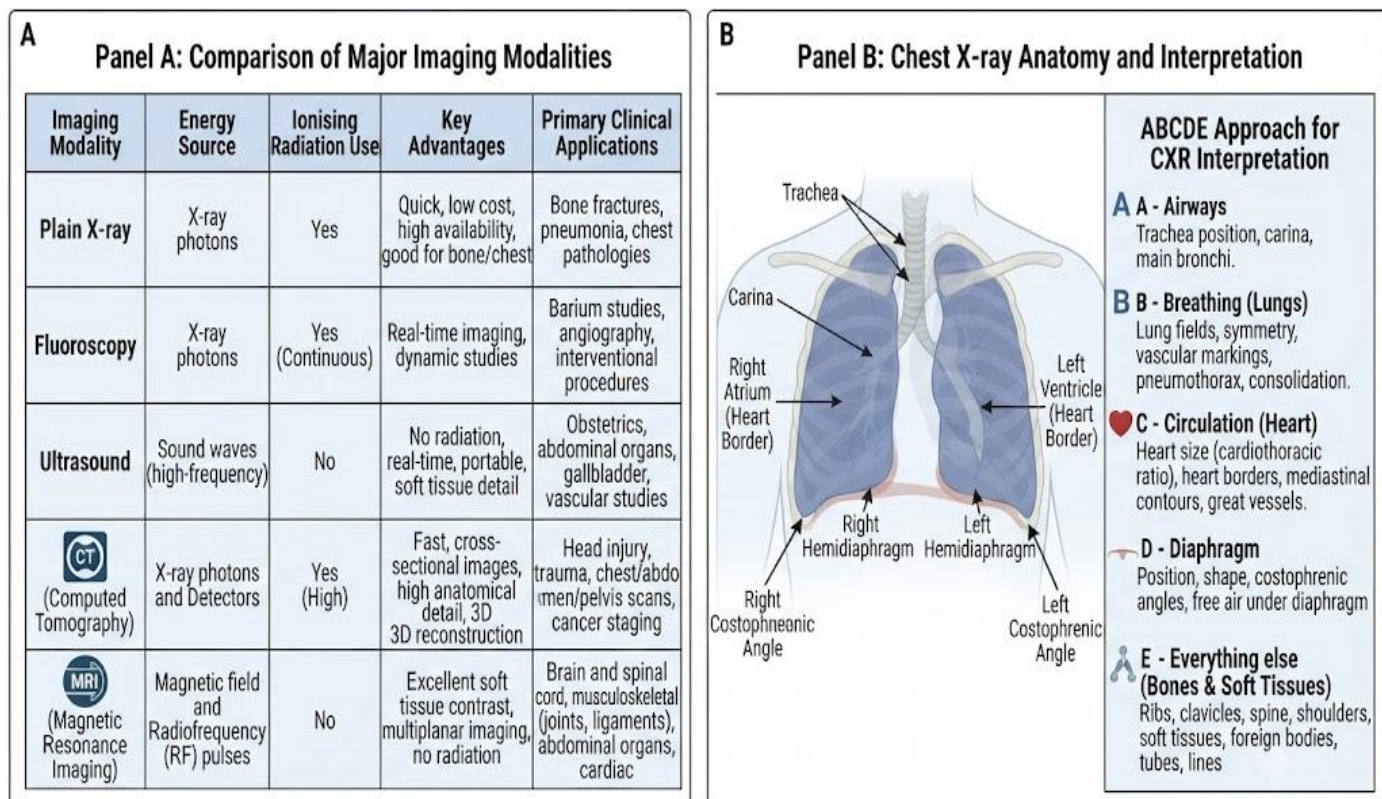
Radiology: imaging modalities and chest X-ray interpretation
